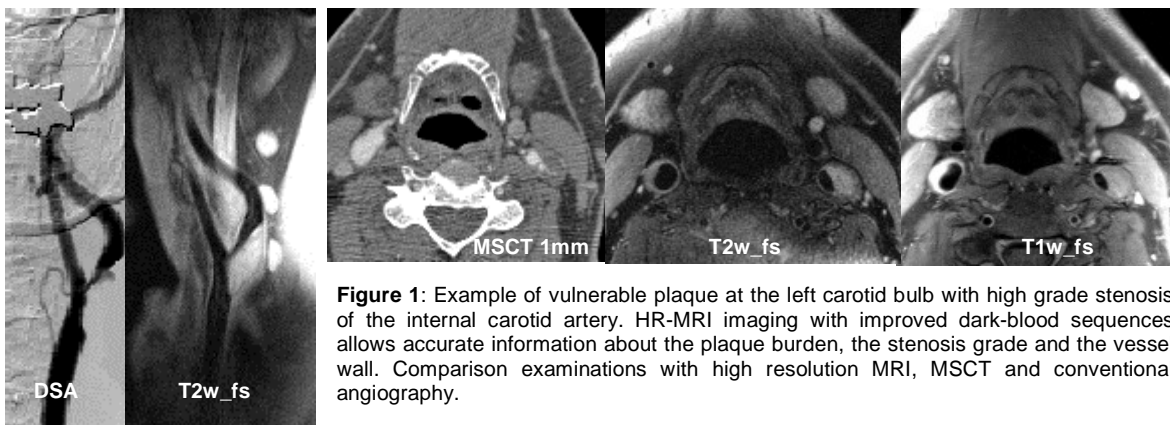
Example of vulnerable plaque at the left carotid bulb with high grade stenosis of the internal carotid artery. HR-MRI imaging with improved dark-blood sequences allows accurate information about the plaque burden, the stenosis grade and the vessel wall. Comparison examinations with high resolution MRI, MSCT and conventional angiography.
